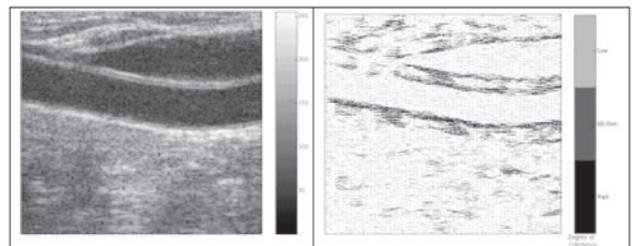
Ultrasound B-mode (left) and Lateral Coherence (right) Images
